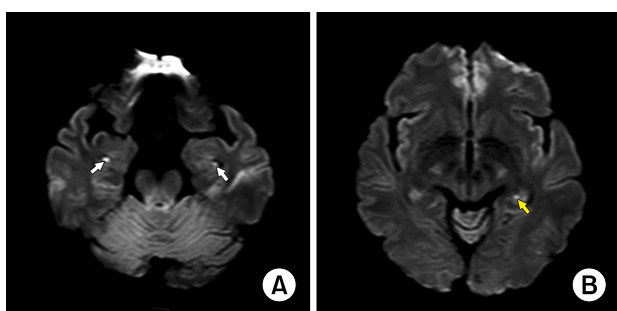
Axial DWI showed small punctate high signal intensity lesions in the CA1 subregions of bilateral hippocampal heads (A; white arrows) and the dorsal part of the left hippocampal body (B; yellow arrow).
